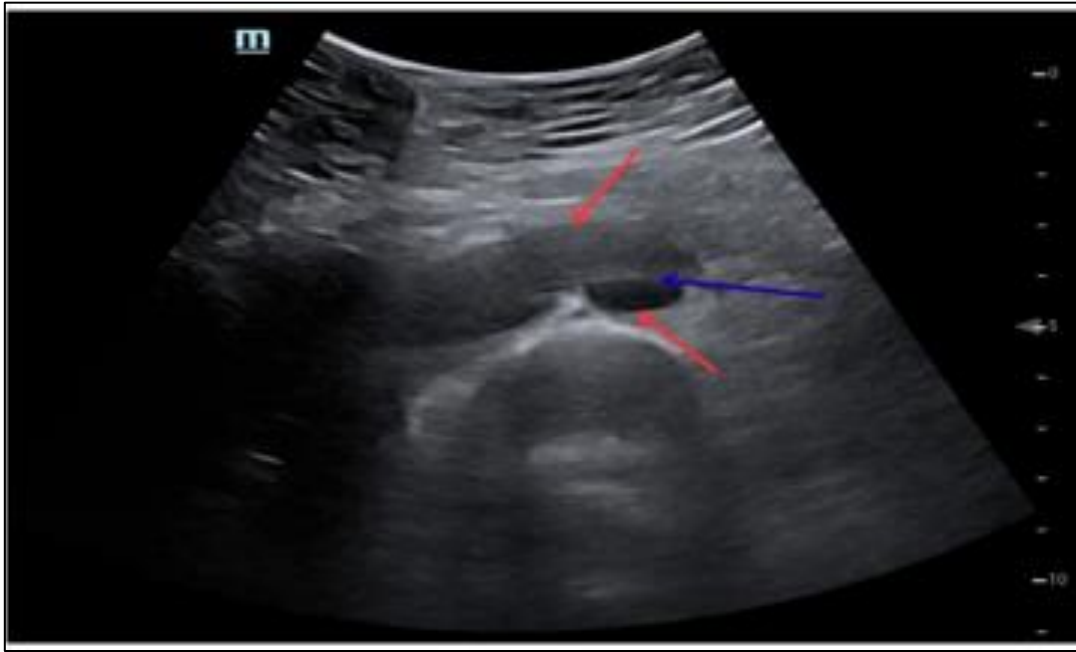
Point-of-Care Ultrasound (POCUS) Showing A Longitudinal View of the Abdominal Aorta. the Origin of the Left Renal Artery Lies in Close Relation to An Intimal Flap, Suggestive of Renal Malperfusion. Red Arrow: Aortic Contours. Blue Arrow: Intimal Flap.
